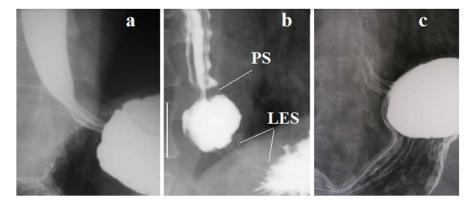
The EGJ radiographs of patients with GERD during abdominal compression. (a) Longitudinal folds in the zone of LES contraction between the esophagus and the stomach indicate an inflammatory process. (b) Reflex contraction of the LES in response to increased pressure in the stomach. Its length (1.7 cm) is 2 times shorter than the normal LES (3.4-4.0 cm). This is the result of the opening of the abdominal part of the LES. Longitudinal folds are visible both at the level of the LES and proximal to the phrenic ampulla. Different forms of folds are due to different pressures. (c) After the intake of barium, its traces were preserved in the longitudinal folds of the LES. PS - proximal sphincter. It is a functional sphincter that arises in the last peristaltic wave to create high pressure in the phrenic ampulla to open the LES and evacuate the bolus from the esophagus to the stomach.
